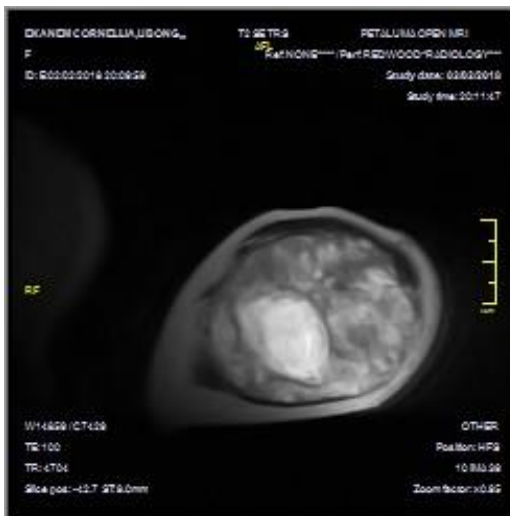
Axial MRI left arm.
